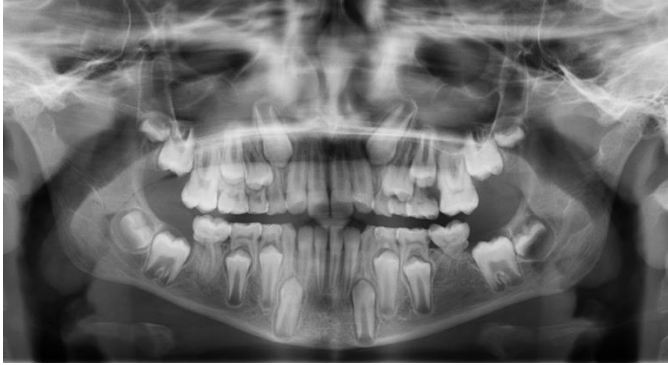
Panoramic X-ray image of the patient.
